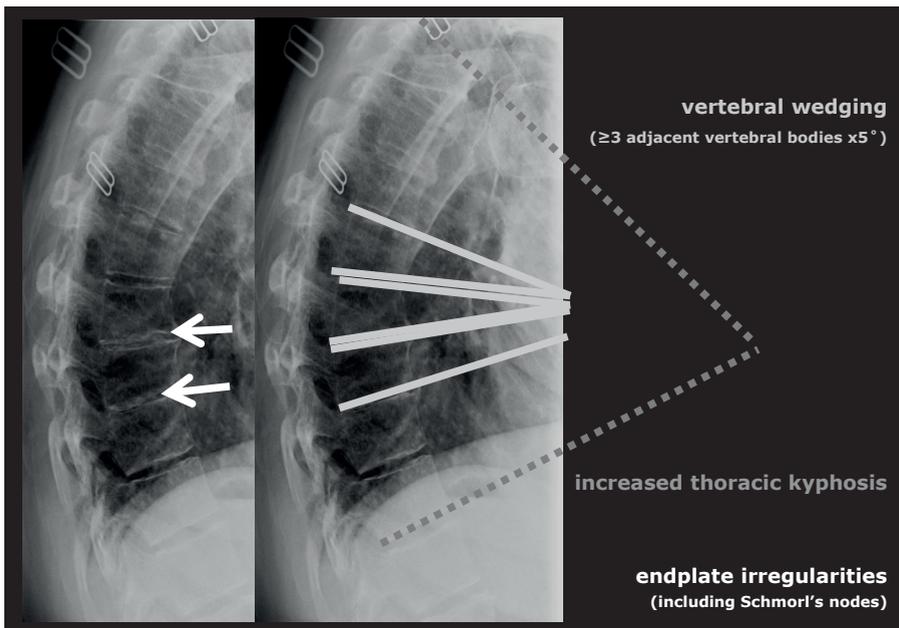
Lateral radiograph showing Scheuermann's disease with marked endplate irregularities (arrows) and mild anterior wedging of multiple midthoracic vertebrae (lines), resulting in increased thoracic kyphosis (dashed arc). The following criteria were applied to define Scheuermann's disease cases: 1) thoracic kyphosis greater than 45° ; 2) at least three adjacent wedge-shaped vertebral bodies of 5° or more; and 3) endplate irregularities including optionally Schmorl's nodes.
